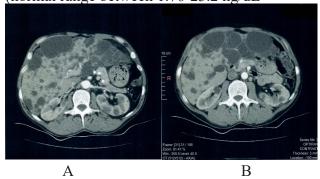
Abdominal CT scan showing multiple hepatorenal cysts (A) and macroadenoma in left adrenal gland (B)
